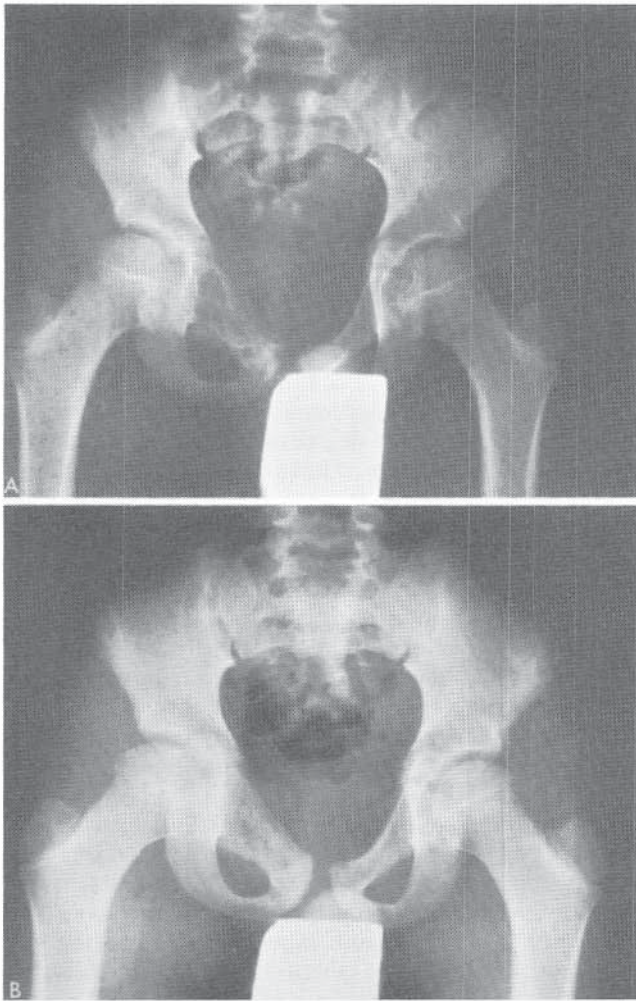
Ewing's sarcoma of the right pubis. A, Initial radiographs. Treatment consisted of irradiation and chemotherapy. B, Nine months later, some healing is apparent. However, the disease metastasized, and the patient died a year later.
